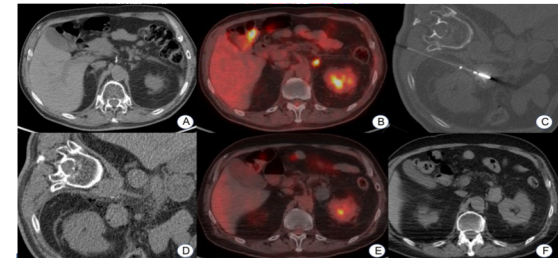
67-year-old male with esophageal adenocarcinoma status post esophagectomy and gastric pull-through surgery found to have a new 1 cm left adrenal lesion on CT scan (A). Hypermetabolism on PET/CT (B) and an adrenal biopsy (not shown) confirmed metastasis. The patient underwent CT-guided RFA (Angiodynamics) 2 months later (C) when the lesion measured 4 cm. Immediate post-ablation CT (D) is without acute complication. Four months after ablation, the PET/CT (E and F) demonstrates no significant FDG uptake or enlargement.
